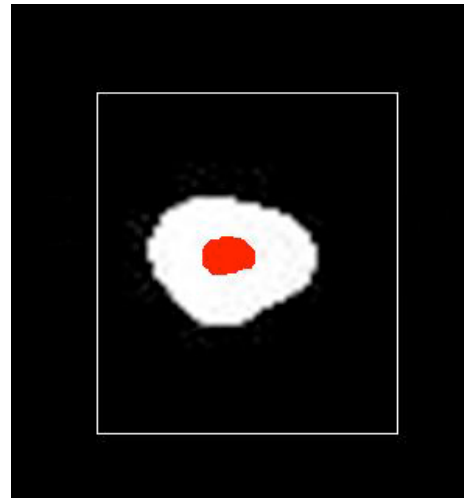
A cross-sectional slice of the tooth obtained by CT, outlining the pulp space.
